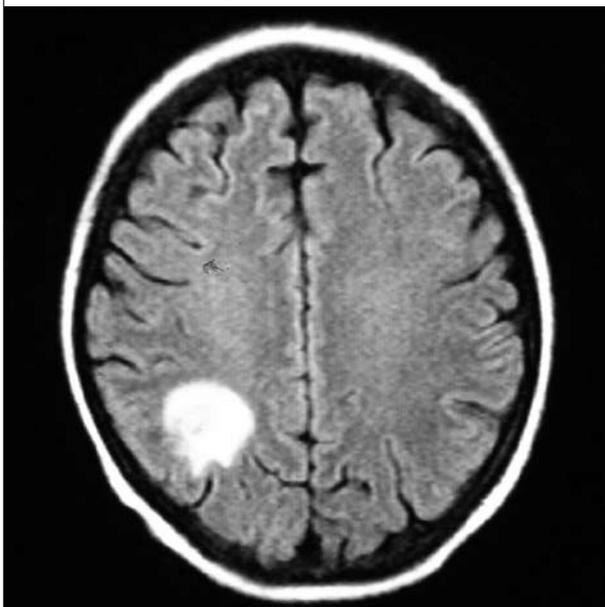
Magnetic resonance imaging shows signs of an abscess in the right occipital cerebrum
